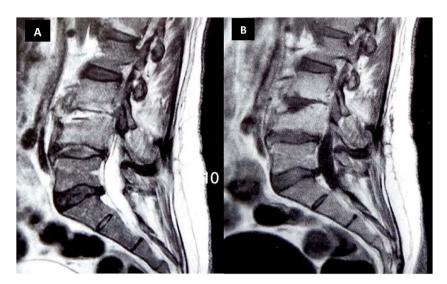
(A) Sagittal T1-weighted after injection of Gadolinium MRI sequence of the lumbar spine shows a heterogeneous hyperintense signal of L3, L4, and the prevertebral soft tissue, associated with an epiduritis, (B) sagittal T2-weighted MRI sequence shows a heterogeneous hyperintense signal of L3, L4, and the intervertebral disc.
